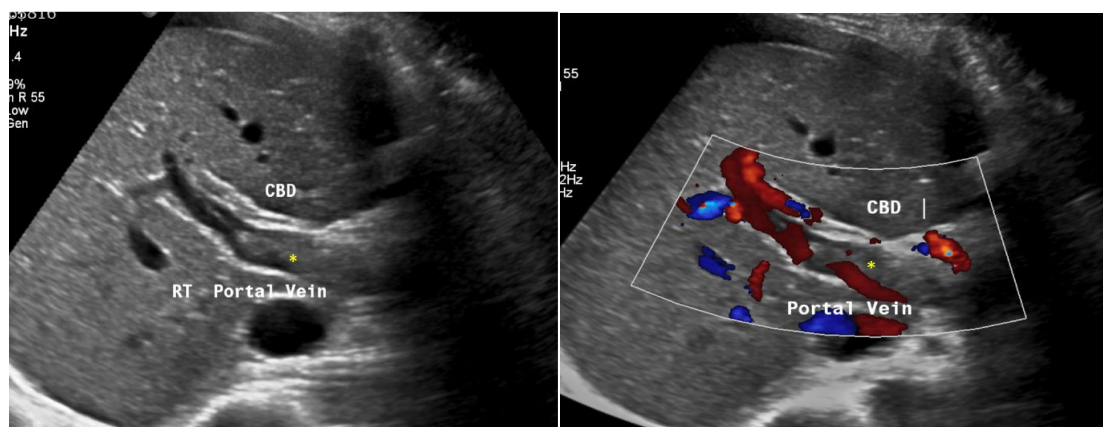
First abdominal ultrasound, showed extensive echogenic thrombus (*) in the right portal vein (left), almost occluded the lumen and causing barely detectable blood flow on colour doppler (right)
